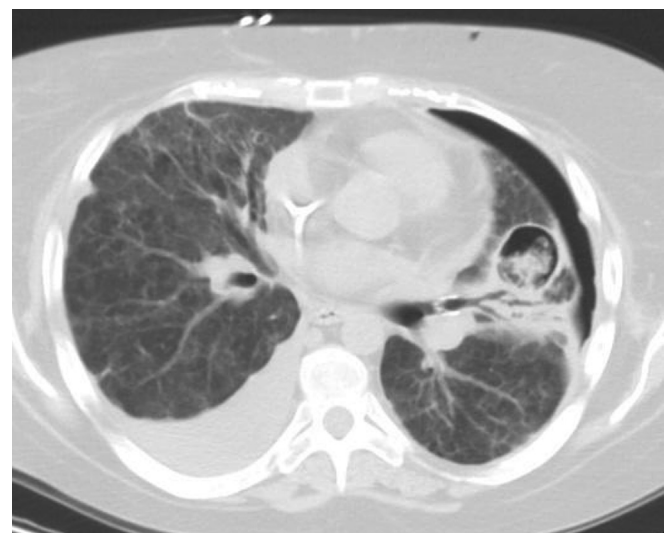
A single axial image from a Thoracic Computed Tomography (CT) scan acquired on Day 110 in a leukaemic patient with Invasive Pulmonary Aspergillosis (IPA). A 4 mm endobronchial valve (Zephyr[®], Pulmonx Inc. Neuchatel, Switzerland) is demonstrated within the lingular segmental bronchus proximal to an alveolar-pleural fistula caused by rupture of a fungal mass lesion. There has been a significant improvement in the previously demonstrated left-sided pneumothorax.
